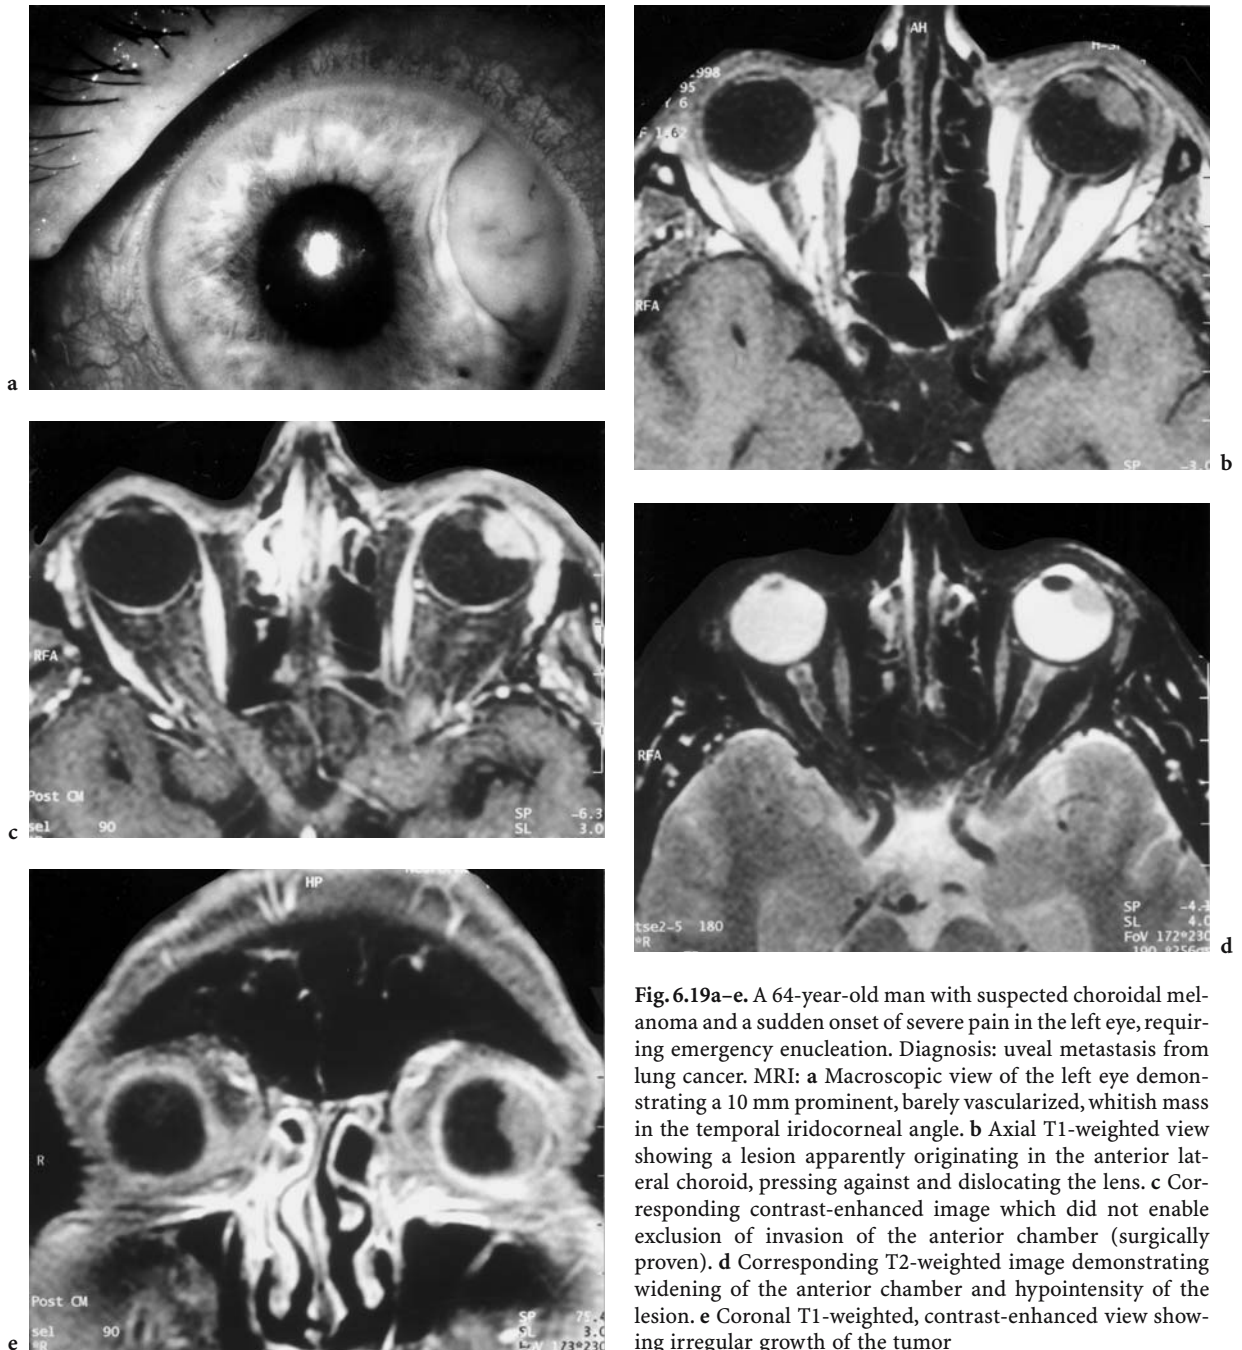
A 64-year-old man with suspected choroidal melanoma and a sudden onset of severe pain in the left eye, requiring emergency enucleation. Diagnosis: uveal metastasis from lung cancer. MRI: a Macroscopic view of the left eye demonstrating a 10 mm prominent, barely vascularized, whitish mass in the temporal iridocorneal angle. b Axial T1-weighted view showing a lesion apparently originating in the anterior lateral choroid, pressing against and dislocating the lens. c Corresponding contrast-enhanced image which did not enable exclusion of invasion of the anterior chamber (surgically proven). d Corresponding T2-weighted image demonstrating widening of the anterior chamber and hypointensity of the lesion. e Coronal T1-weighted, contrast-enhanced view showing irregular growth of the tumor
